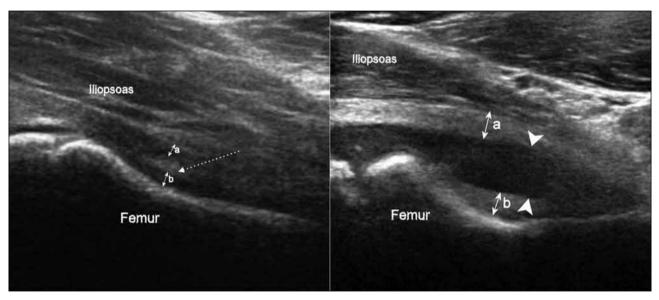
Normal sonographic image of a paediatric hip: the anterior joint capsule lies deep to the iliopsoas muscle and consists of an anterior layer (a) and a posterior layer (b) separated by a thin echogenic line (dotted arrow). These two layers are separated in the presence of joint effusion (arrowheads).
